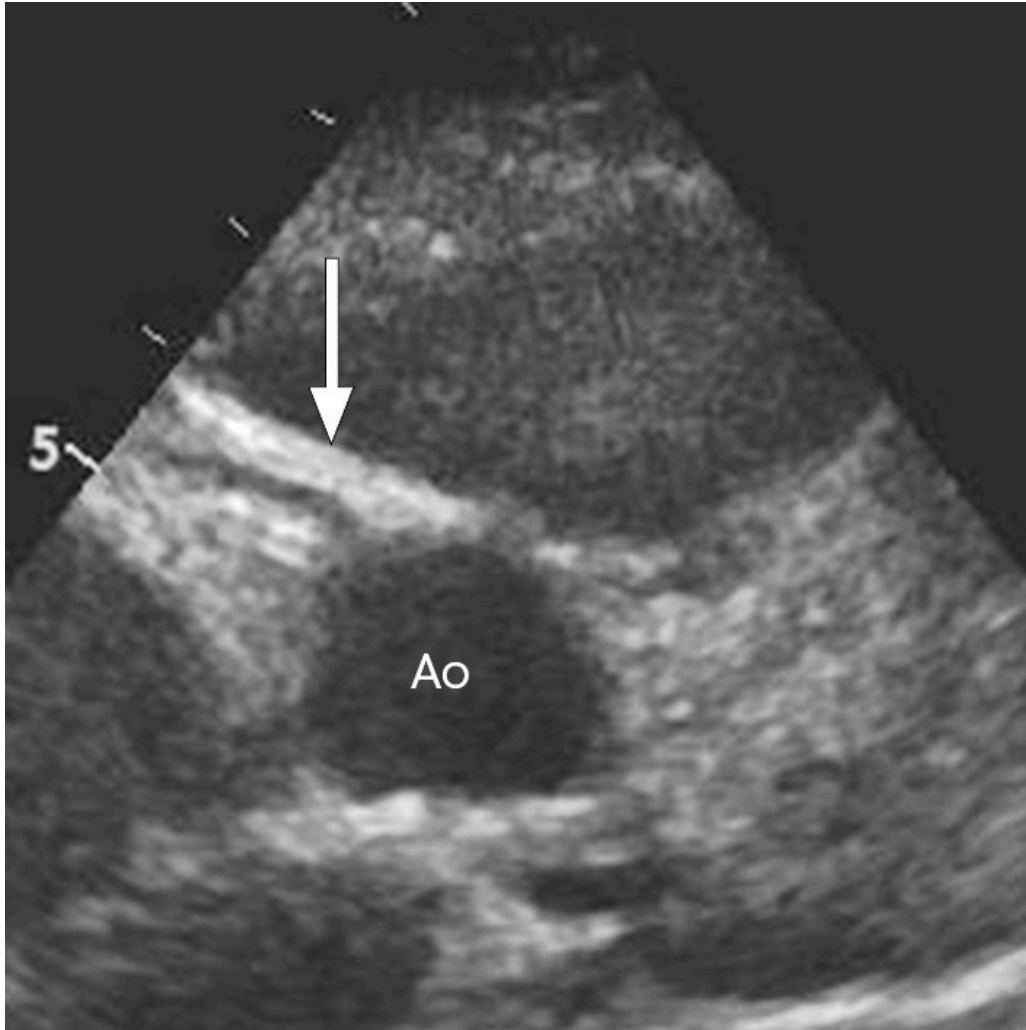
Echocardiogram of the aorta in cross-section (Ao) showing the exit point of the right coronary artery (arrow). The right coronary artery has increased echo in the vessel wall, which can be seen in the acute stage of Kawasaki syndrome.
